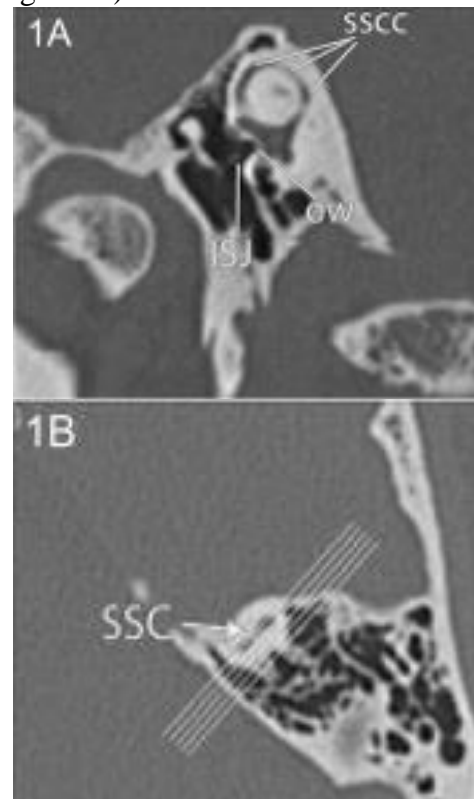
(A) Poschl-view CT reformats showing the whole superior semicircular canal (SSCC) (ISJ; incudostapedial joint, OW; oval window). (B) Axial CT image close to the dome of superior semicircular canal showing the reformatting plane (lines).⁴
